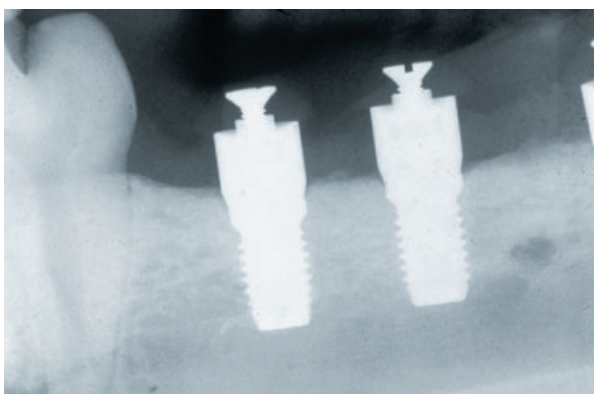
Radiograph obtained from the implants in the right side of the mandible.
